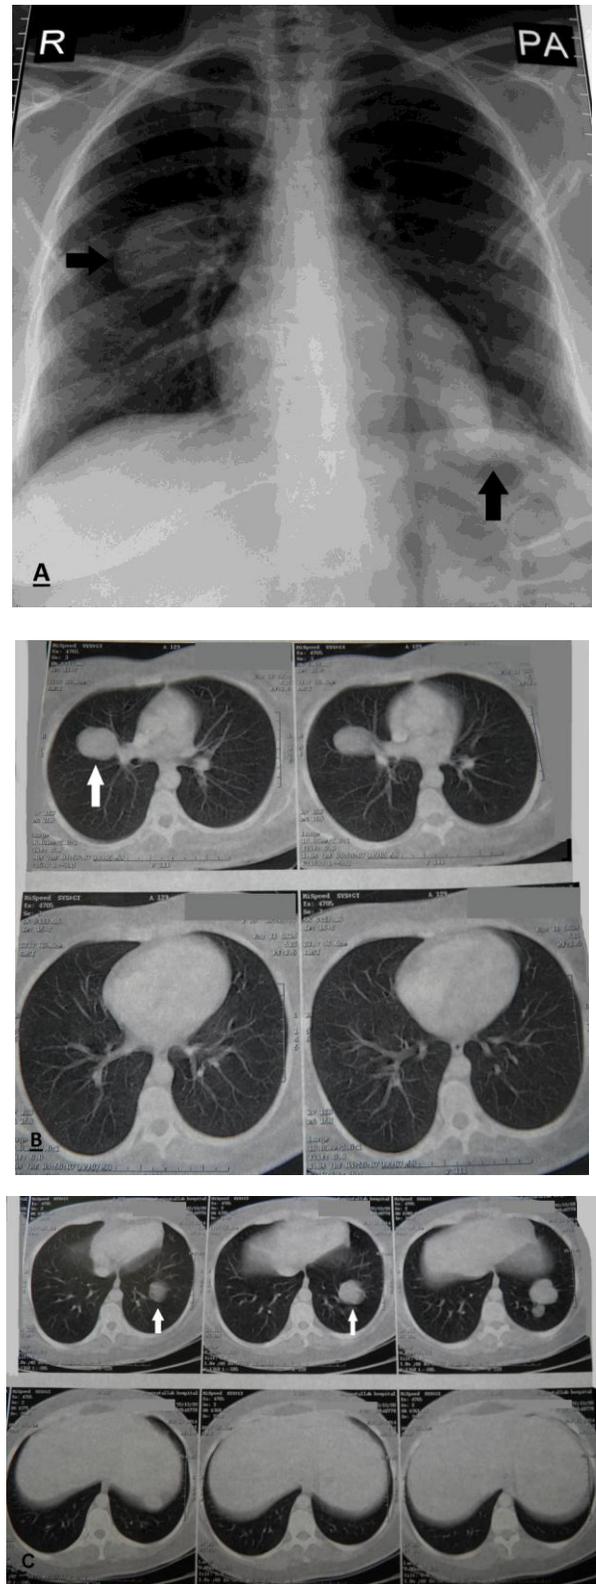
Bilateral intact cystic lesions on chest X ray (A) and CT scan (B & C) (arrows)
